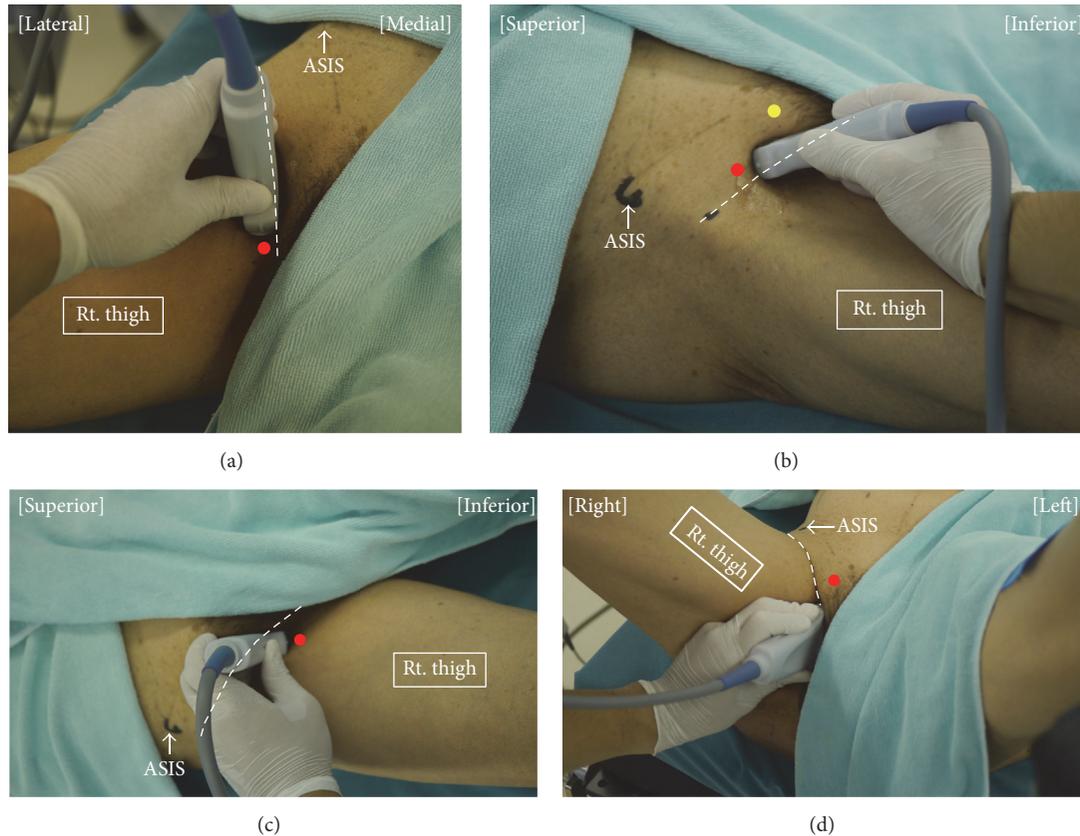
Patient and transducer positions for performance of each ultrasound-guided right-sided obturator nerve block technique. The dotted lines indicate the inguinal crease. (a) The patient is placed in the supine position with his hip slightly abducted and externally rotated. In the distal approach for obturator nerve block, the transducer is placed medial to the femoral vein, along the inguinal crease, perpendicularly to the skin. A needle is inserted from the point indicated by the red circle, in-plane with the transducer, in a medial-to-lateral direction. (b) The transducer is tilted cranially from the position shown in Figure 2(a) to obtain an ultrasound image similar to that in Figure 3(b). A needle is inserted from the point indicated by the yellow circle in an anterior-to-posterior direction using out-of-plane ultrasound guidance in the approach devised by Taha [23]. In the approach used by Lin et al. [42], a needle is inserted from the point indicated by the red circle, in a lateral-to-medial direction, using in-plane ultrasound guidance. (c) The technique described by Akkaya et al. [35] can be performed with the patient in a supine position and his/her leg straight. The transducer is placed in the sagittal plane on the inguinal crease between the femoral vein and the pubic tubercle. A needle is inserted from the point indicated by the red circle, in-plane with the transducer, in an inferior-to-superior direction. (d) In the approach devised by Yoshida et al. [31], the patient is placed in the lithotomy position. The transducer is placed immediately lateral to the perineum on the medial aspect of the thigh along the extended line of the inguinal crease and orientated cephalad. A needle is inserted 2-3 cm cephalad from the anterior side of the transducer (red circle) and advanced in-plane with the transducer in an anterior-to-posterior direction. ASIS, anterior superior iliac spine.
